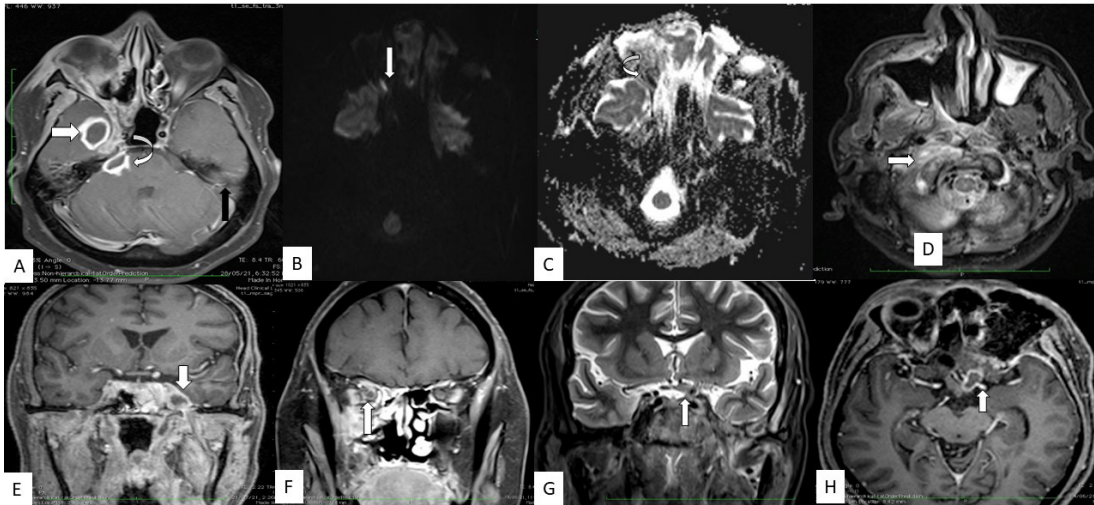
2H. 2A: T1 axial Fat sat post contrast image shows ring enhancement over the right prepontine region (curved arrow) and ring enhancement in right temporal lobe (block arrow) suggestive of extra axial abscess in pre pontine cistern and temporal abscess. 2B and 2C: DWI and ADC images show increased diffusion restriction and low ADC over the right optic nerve (block and curved arrow) suggestive of right optic nerve infarction. 2D: Axial T2 weighted STIR image shows hyperintensities in right half of anterior arch of C1 vertebra (block arrow) consistent with osteomyelitis. Associated adjacent prevertebral soft tissue thickening seen. 2E: Coronal T1 Fat Sat post contrast image shows peripherally enhancing abscess in left para cavernous region (block arrow). 2F: T1 coronal Fat Sat post contrast image shows perineural enhancement along the right optic (block arrow) nerve suggestive of optic perineuritis. 2G: Coronal STIR image shows thickening of pre chiasmatic segment of left optic nerve (block arrow) – consistent with extension of infection along the nerve. 2H: Axial T1 Fat Sat post contrast image shows peripherally enhancing abscess along prechiasmatic segment of left optic nerve (block arrow).
